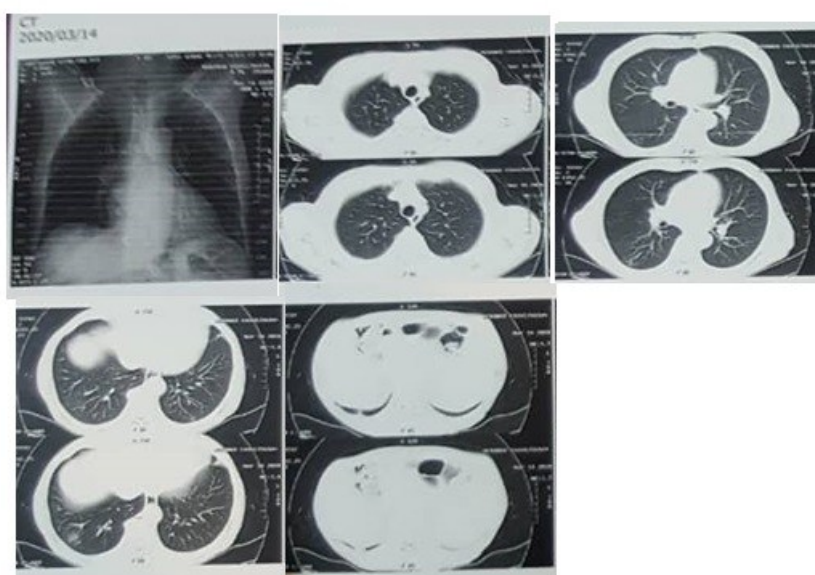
Chest computed tomography radiograph.
